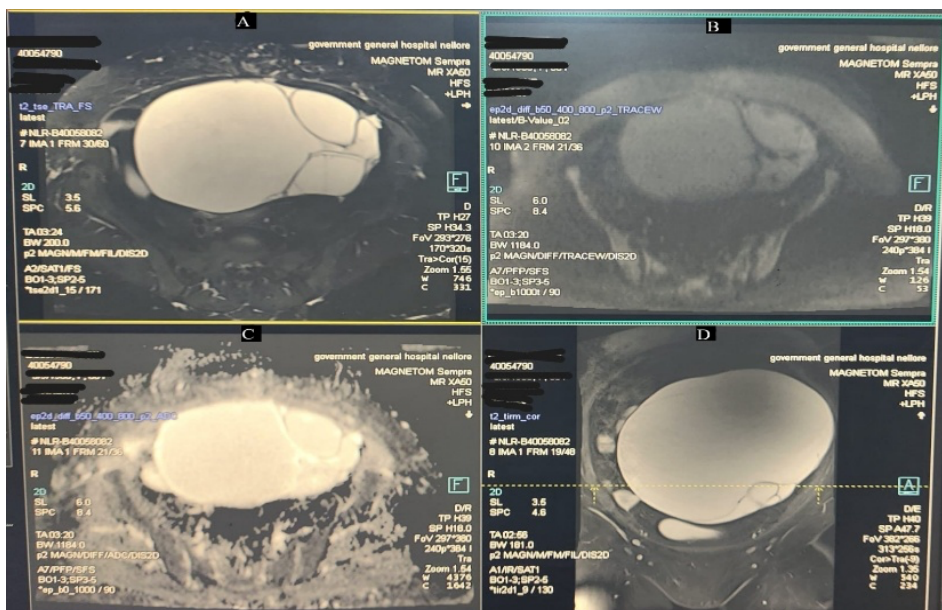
A. Axial T2 weighted image of MRI pelvis showing well defined hyperintense lesion with thin hypointense internal septations. B. DWI image at b1000 showing no Restricted diffusion in the lesion. C.ADC image showing facilitated diffusion in the lesion. D. Coronal T2 weighted image showing eccentric internal septations
